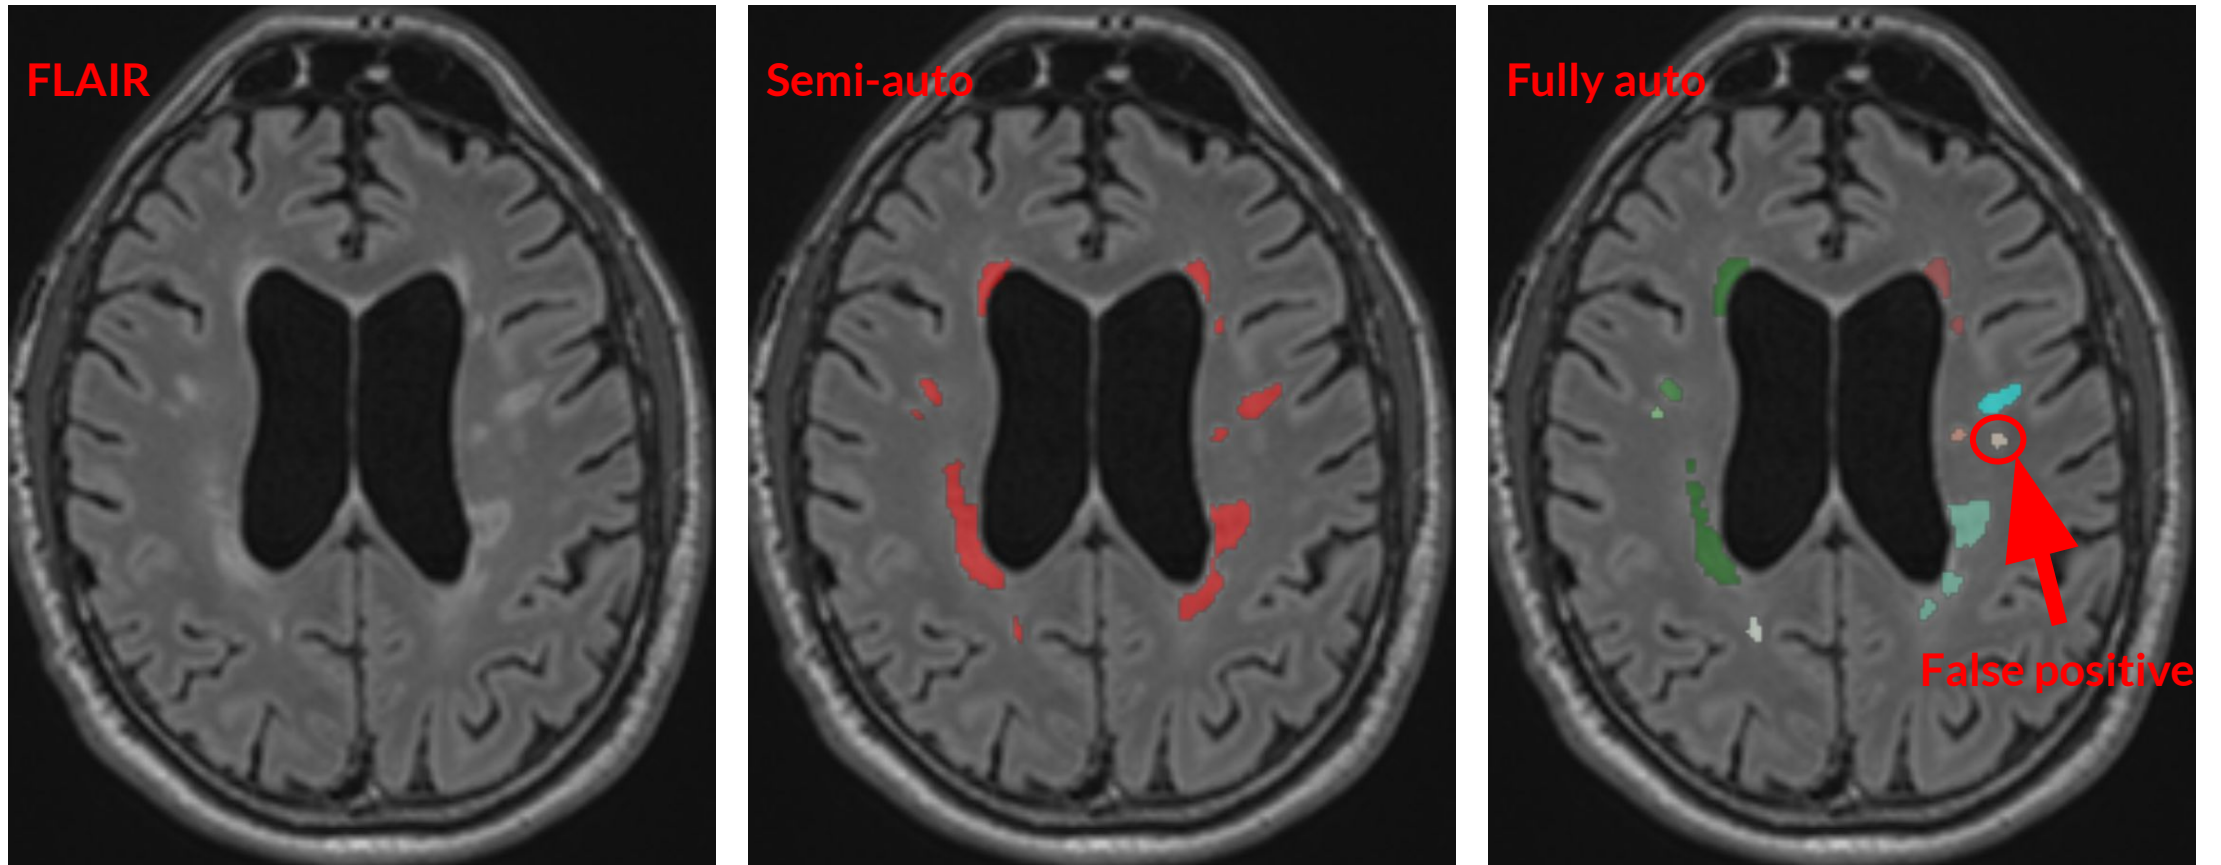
Axial slice of three MR images from a same MS patient, same visit.
